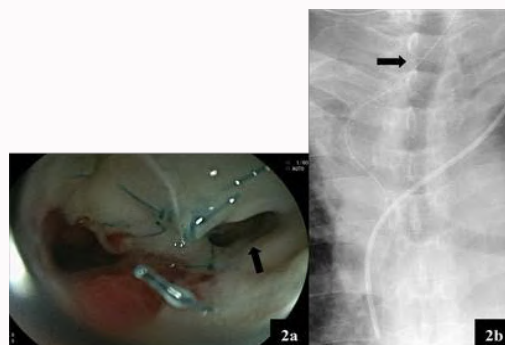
a: Upper endoscopy showed a fistula on the right wall of the suture line (arrow). b: The transesophageal drainage catheter was inserted into the mediastinal abscess through the fistula (arrow), assisted by endoscopy.
